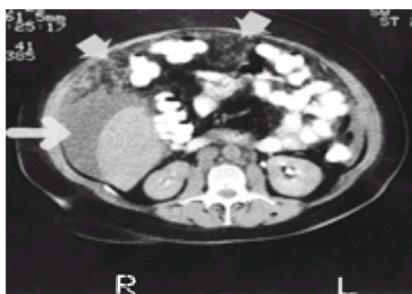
Computed tomography scan of the abdomen of a 66-year-old woman with stage IV ovarian cancer. The short arrows indicate areas of peritoneal thickening and infiltration. The large horizontal arrow indicates ascitic fluid interposed lateral to the lower lobe of the liver. L, left; R, right.
